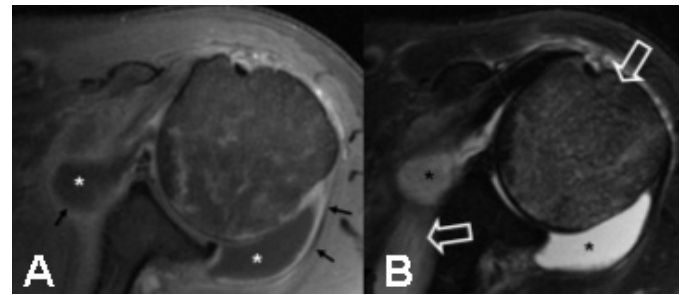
Axial T1 weighted image following gadolinium injection, (A) and axial T2 weighted, (B) MRI of the left shoulder. A large joint effusion (asterisk) with peripheral enhancement (arrow) is noted. Additionally, edema of the humeral head and adjacent soft tissues is shown (B, open arrow).
